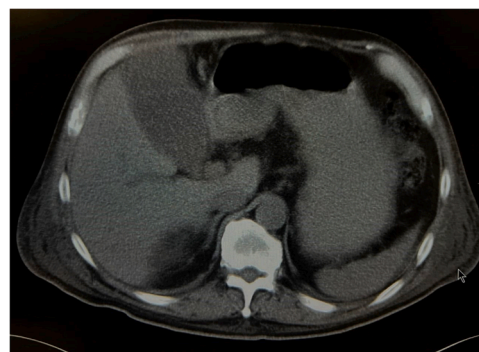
Computed tomography scan of the abdomen showing thickening of the gallbladder wall.
